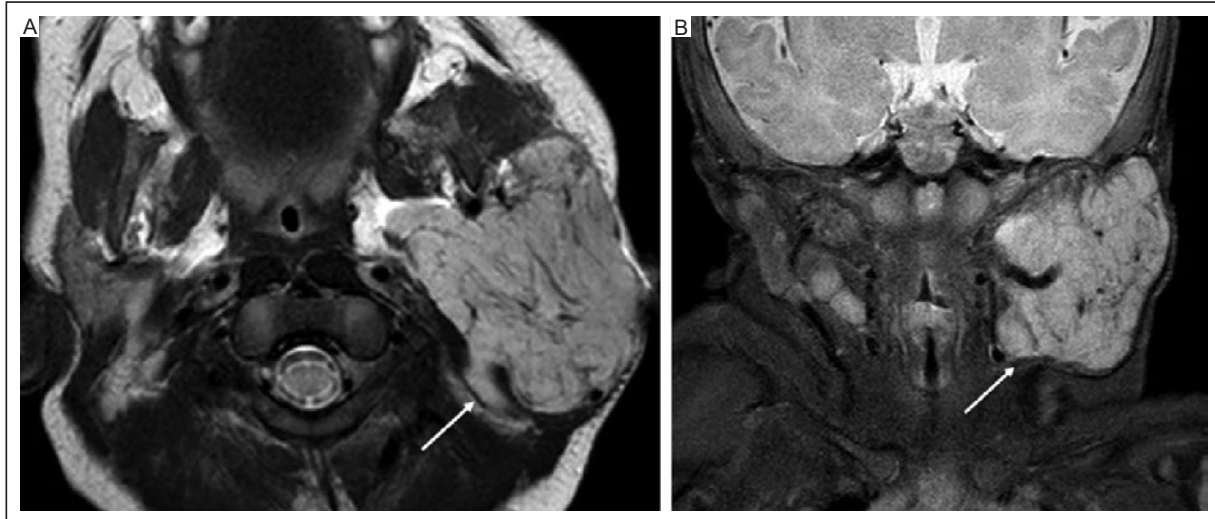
Infantile hemangioma. A: axial T2-weighted, and B: coronal T2-weighted fat-suppressed MRI of the neck of a 3-month-old boy shows a large T2 hyperintense lesion in the left anterior neck with multiple T2 hypointense internal flow voids consistent with an infantile hemangioma (arrows).
